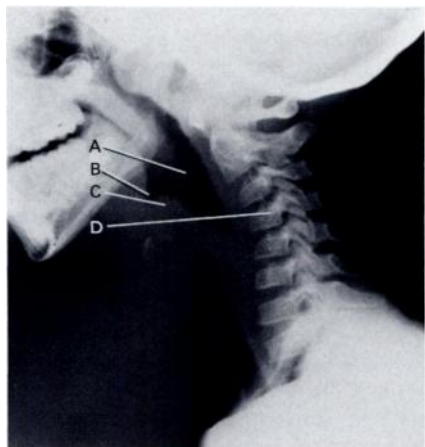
Lateral radiograph of the neck of a patient with epiglottitis: A, dilated hypopharynx; B, reduced size of vallecula due to encroaching swollen epiglottis; C, rounded, thickened epiglottis ("thumb sign") with swollen aryepiglottic folds extending posteriorly and inferiorly; D, reversed cervical curvature. This radiograph does not demonstrate an open mouth and protruded mandible characteristic of more advanced obstruction.
